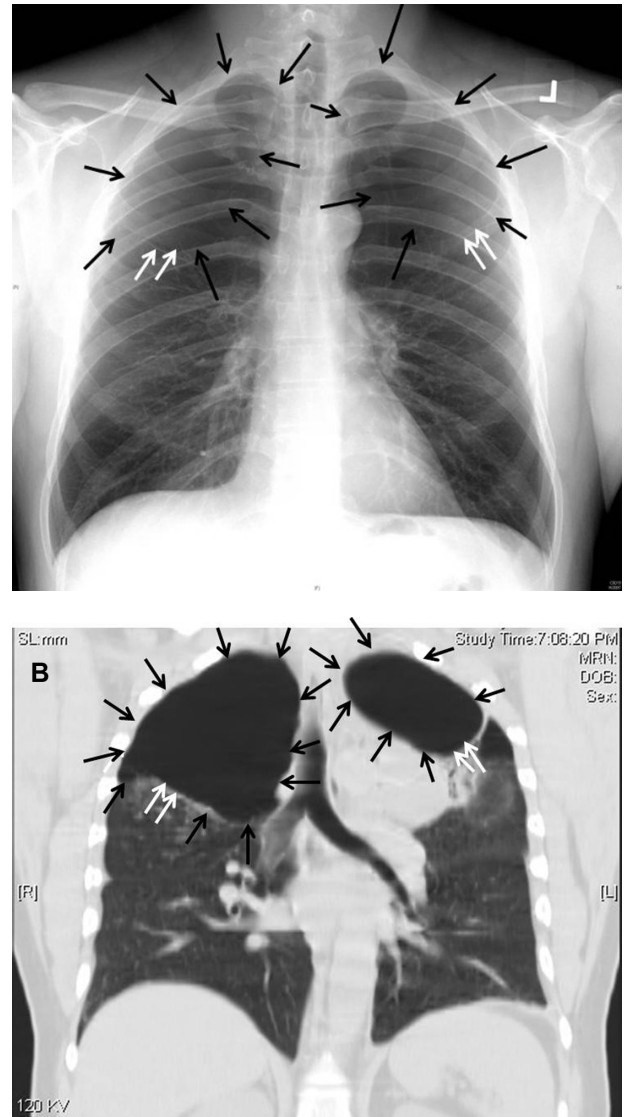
(A) Chest radiograph prior to admission showing hyperinflated lungs, biapical bullous disease as evidenced by lucency without lung markings (black arrows). Note inferior border of bullae is seen (double white arrows). (B) Computer tomography at admission with coronal reformatted images confirms the bullous disease (black arrows); inferior border of bullae (double white arrows).
